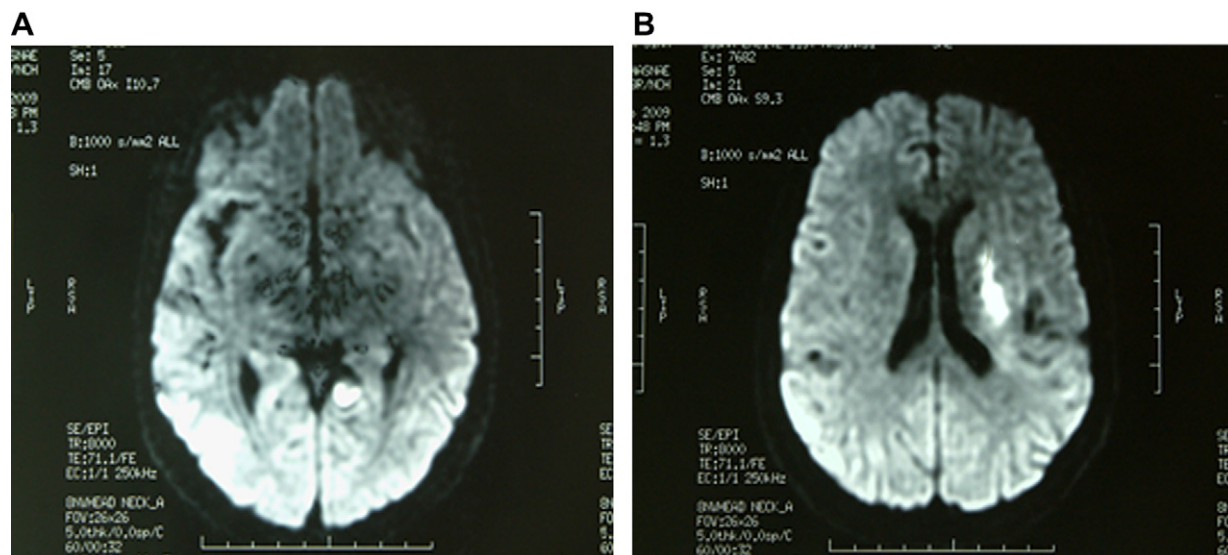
Axial MRI of the brain. Apparent diffusion coefficient sequence shows hyperintense lesion in parahippocampal (A) and paraventricular (B) territory.
